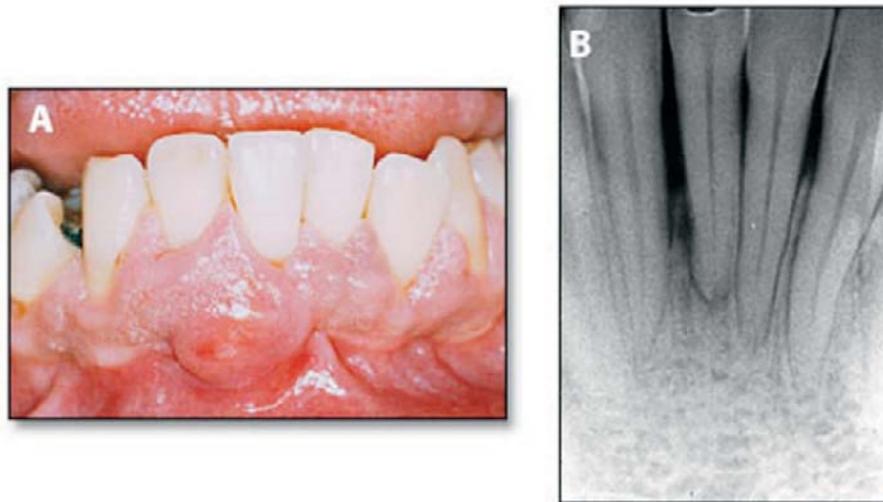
Periodontal abscess in a patient with untreated periodontitis: (A) clinical and (B) radiographic characteristics.
